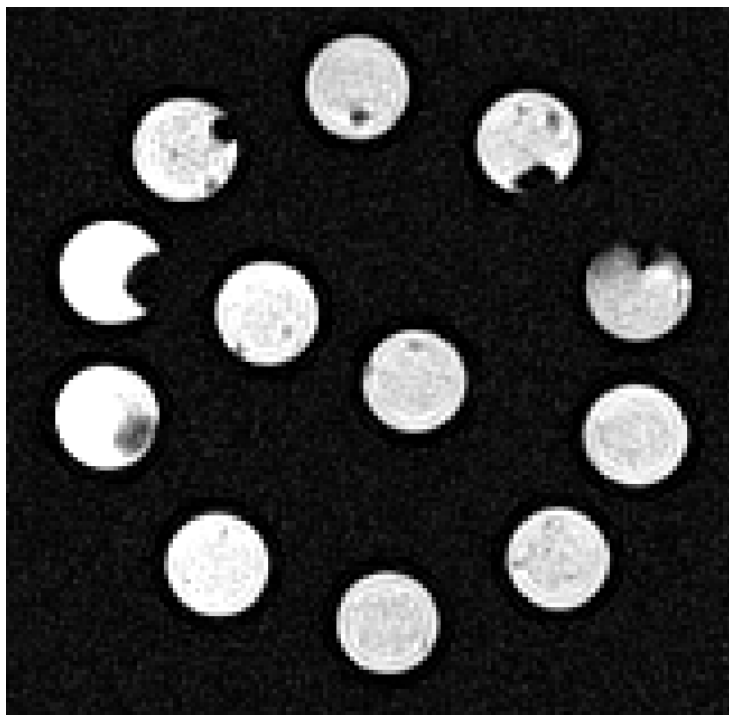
MR image of the gel samples at 1.5 T acquired with a FSE sequence.
